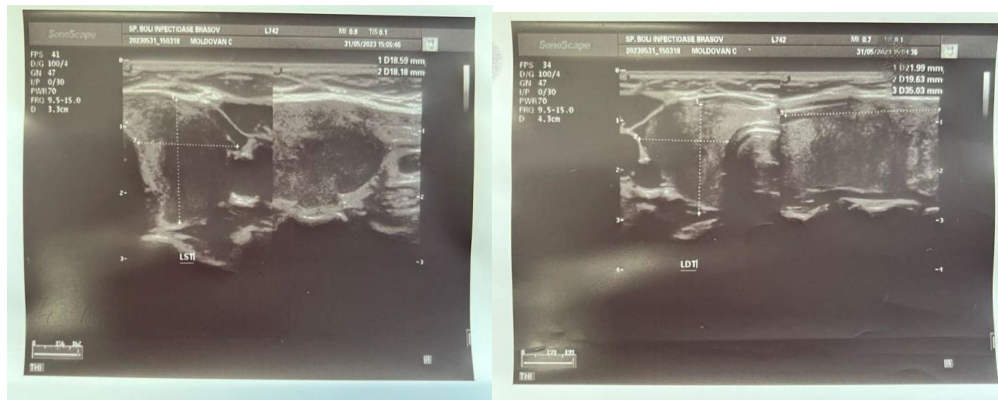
Ultrasonography of the thyroid gland*
